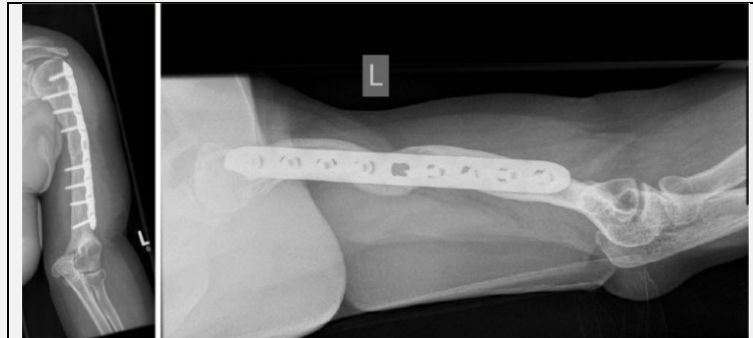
X-rays at the patient's 2-year follow-up appointment.
